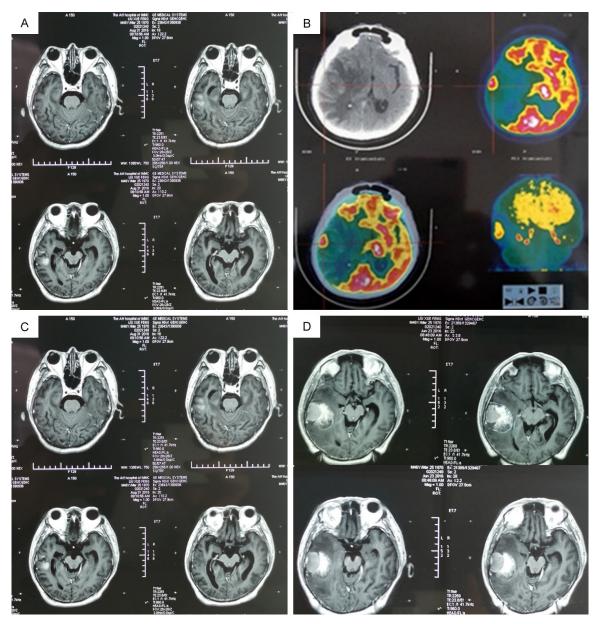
Right temporal lobe brain metastasis (lung cancer: moderately poorly differentiated adenocarcinoma). A. Intraoperative enhanced localization MRI; B. ¹⁸F-FDG PET/CT imaging; C. Intraoperative enhanced localization MRI; D. Enhanced MRI at 2 months after the treatment.
